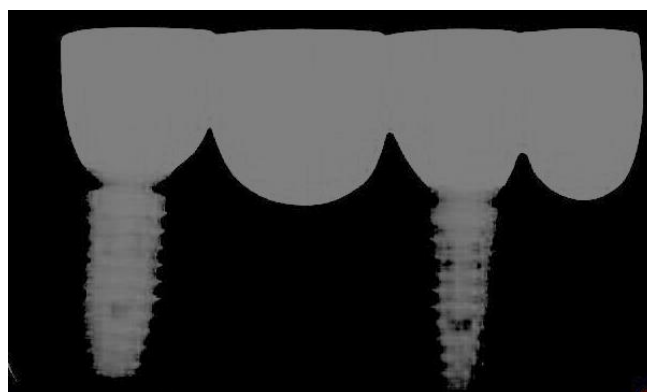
X-ray check seating of the implant-abutment connection
